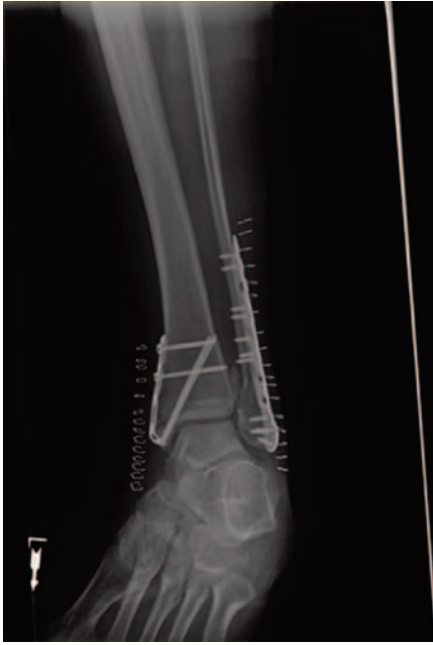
Final intraoperative appearance of the double plated fibula with concurrent post-operative radiographs.
